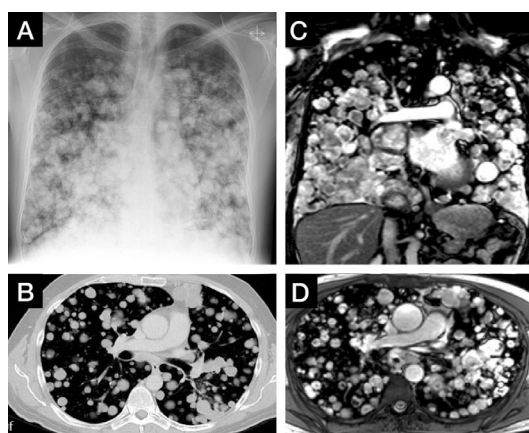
Bilateral multiple, rounded, well-defined lesions are seen in posteroanterior chest radiograph (A), axial plane of CT study in maximum intensity projection (B) and MRI images of steady-state free precession sequence in coronal and axial plane (C, D). The chest radiograph was acquired a year prior to the CT and MRI studies.
